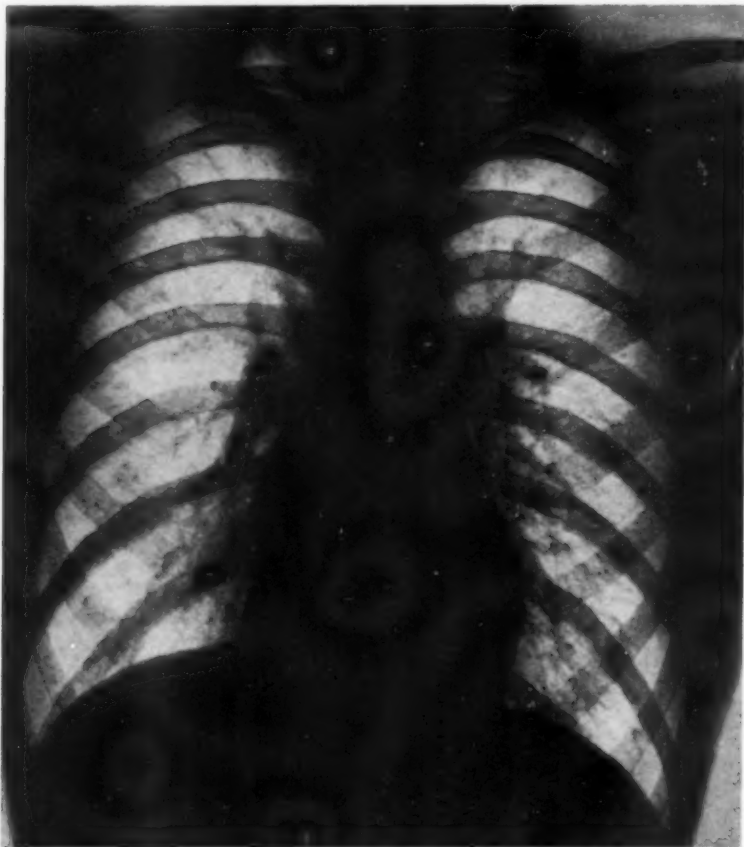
Roentgenogram (September 30). Resolution complete except for exaggeration of truncal markings at the bases.
